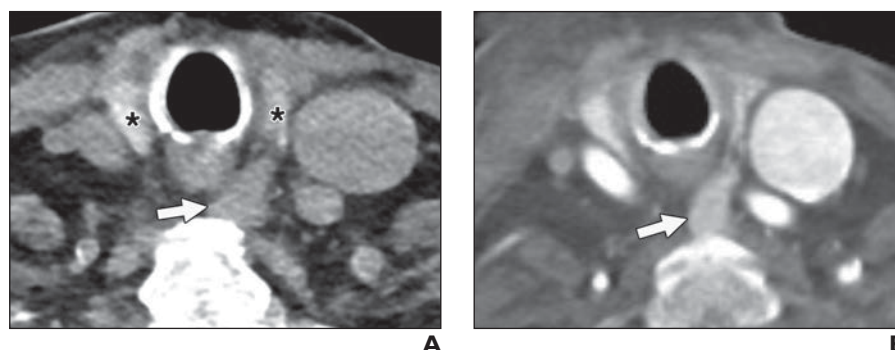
85-year-old woman who underwent noncontrast cervical spine CT followed by contrast-enhanced neck CTA owing to neck pain after falling at home. A and B, Axial images from cervical spine CT (A) and neck CTA (B) show soft-tissue nodule (arrow) along posterior aspect of left thyroid lobe. Nodule is hypoattenuating relative to adjacent thyroid gland (asterisks, A) on cervical spine CT and exhibits hyperenhancement relative to cervical lymph nodes (not shown) on neck CTA. Interpreting neuroradiologist suspected this finding to represent opportunistically identified enlarged left superior parathyroid gland and included in clinical report recommendation for biochemical evaluation for possible primary hyperparathyroidism. Recommended laboratory testing was performed and yielded results consistent with primary hyperparathyroidism.
